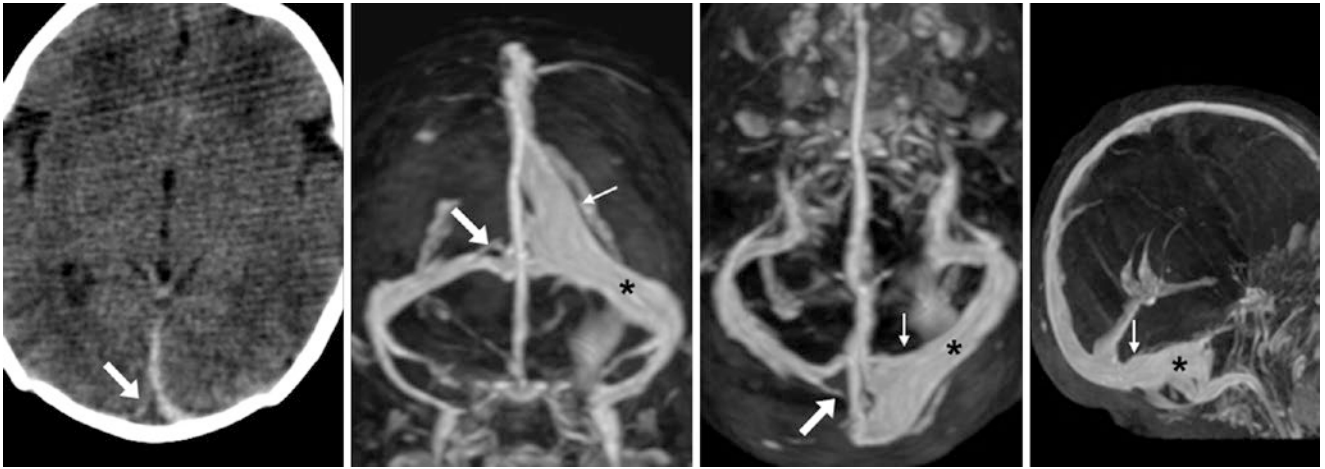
Dorsal SSS “split.” A 5-day-old, in whom thrombus was questioned on nonenhanced CT (*left*), owing to a spurious filling defect within a hyperdense SSS (*arrows*). However, CEMRV MIPs in PA (*left middle*), superior (*right middle*), and RPO (*right*) views did not identify
